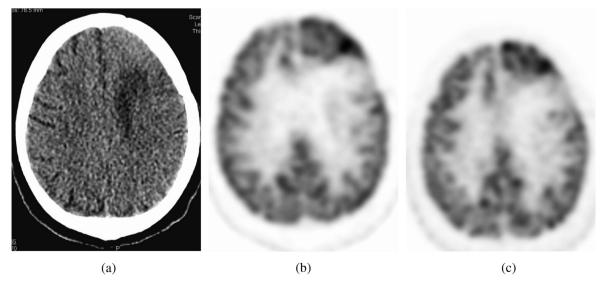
50 years old patient with left frontal low grade glioma by noncontrast CT (a), early (b) and late (c) PET images showed, early SUVmax of the lesion = 6 and 4.7 in the late scan, difference of -21.7%, the GM early SUVmax was 7.8 and 5.9 in the late scan, difference of about -24.4%, and the ratio between the lesion and gray matter uptake was 0.77 in the early and 0.80 in the late phase with L/GM difference of 3.6%.
